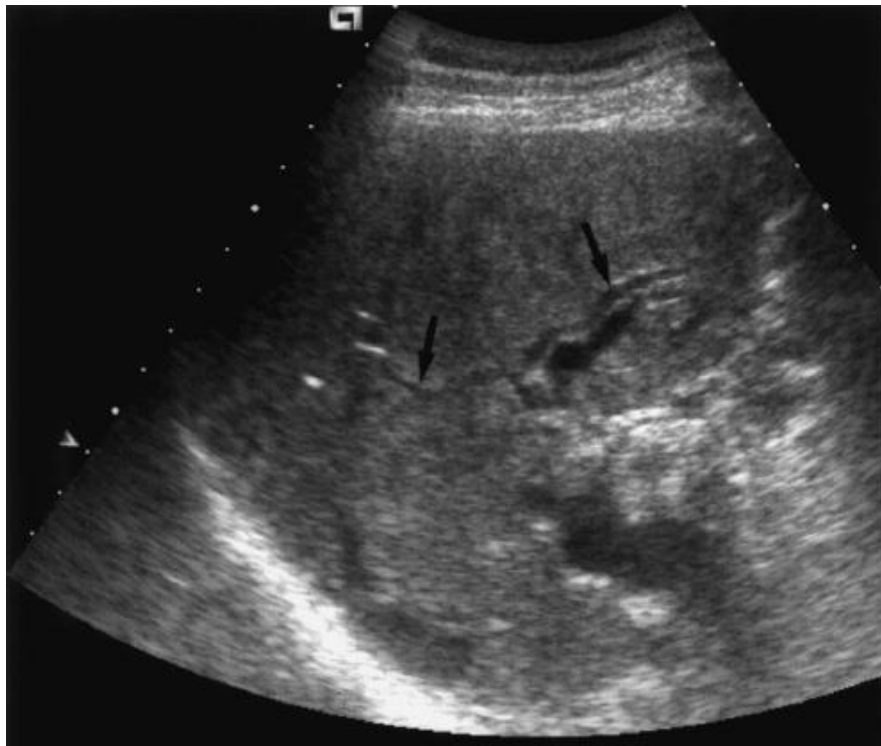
Ultrasound image for transplanted liver (Beeser et al, 2016).
